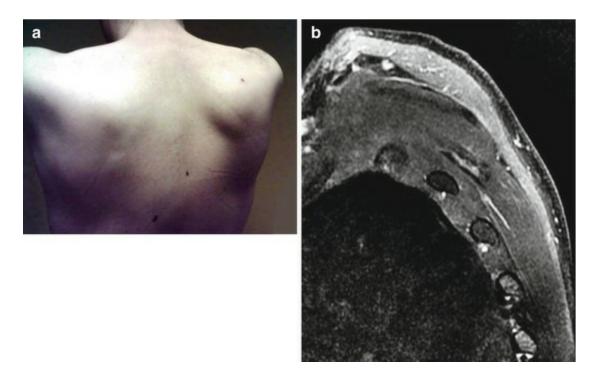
A 43-year-old patient with neuropathy in the left accessory nerve. (a) Photograph of the patient shows left scapular winging. (b) Strictly oblique sagittal fat-suppressed T2-weighted MRI of the shoulder shows edema of the trapezius
